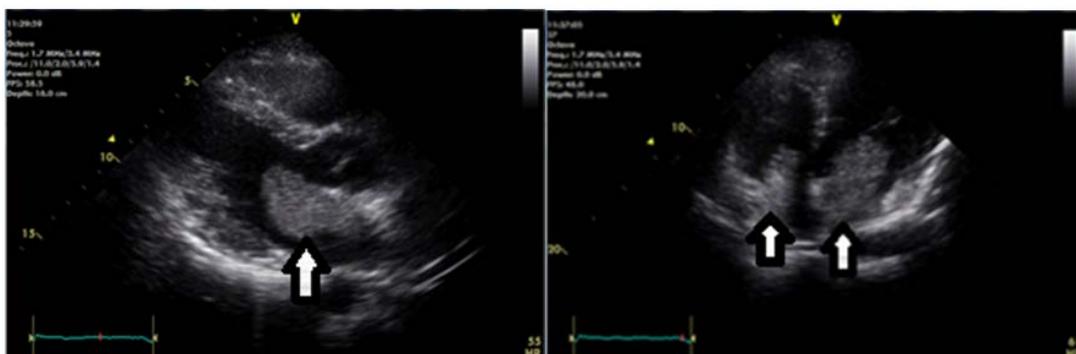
Transthoracic echocardiography of left atrial tumor prolapsing in to left ventricle in diastole from parasternal long axis view at left and biatrial tumors from apical four chamber view at right (arrows)
